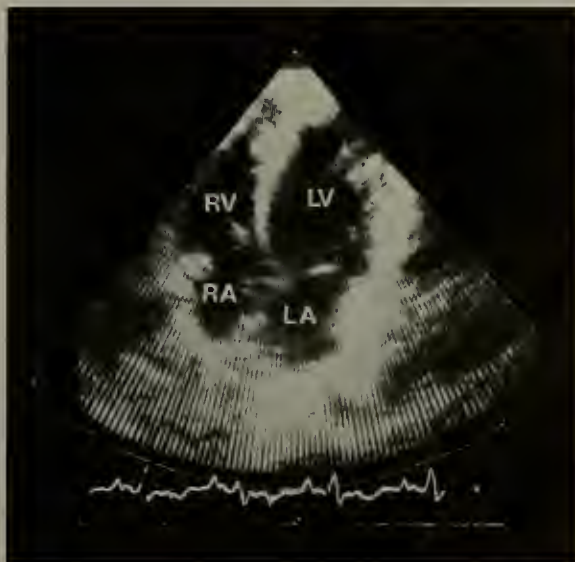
Great advances have been made over the last 30 years in imaging (looking at) the heart. The top picture shows a chest X-ray taken in the 1940's. All that can be told from such pictures is the overall size of the heart and the shape of the silhouette. The internal cardiac structures are not visible, nor is it possible to determine whether the shadow is created by an enlarged heart or whether there might be fluid in the sac surrounding the heart.
